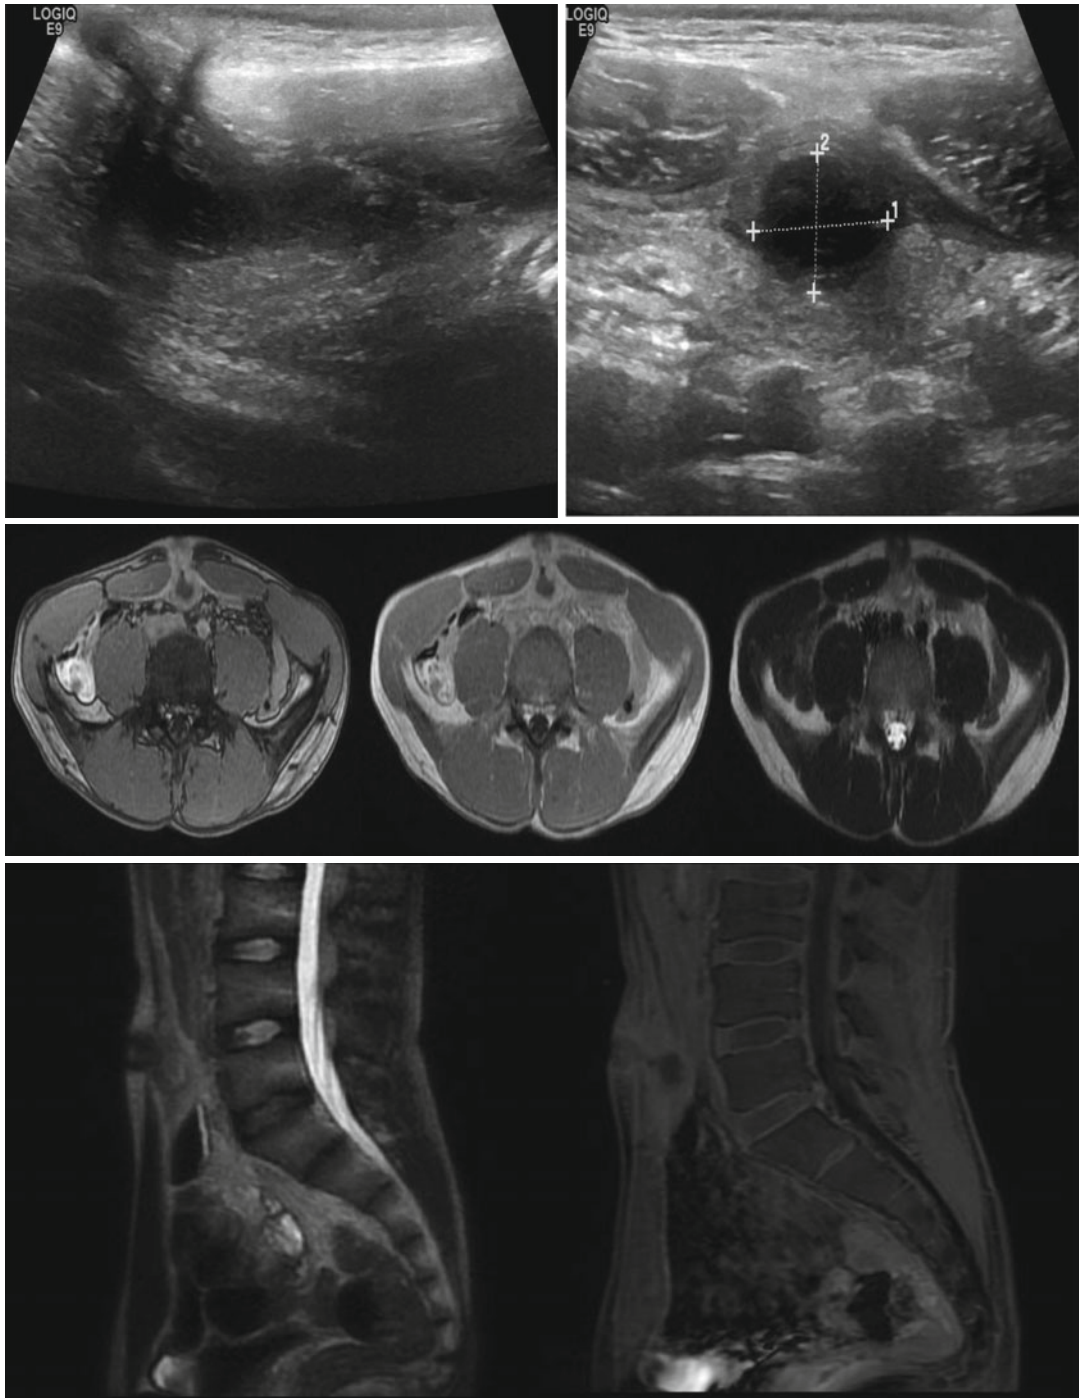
The first two ultrasound images show, in the context of the subcutaneous tissue in the lower periumbilical, a corpuscular anechoic mass, surrounded by fatty tissue dimly hyperechogenic (urachal complicated cysts). The diagnostic study continues through MRI T1-weighted
